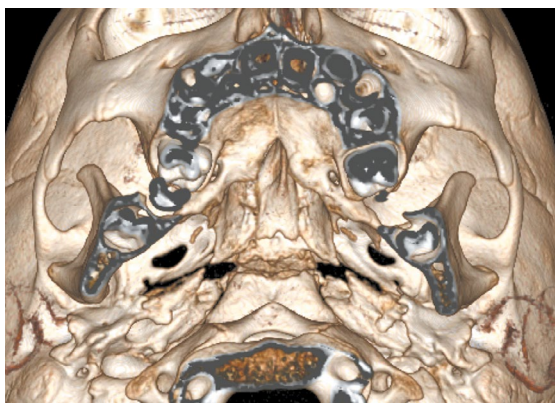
Wedge-shaped defect of the hard palate on a three-dimensional computed tomography reconstructed image of the skull
